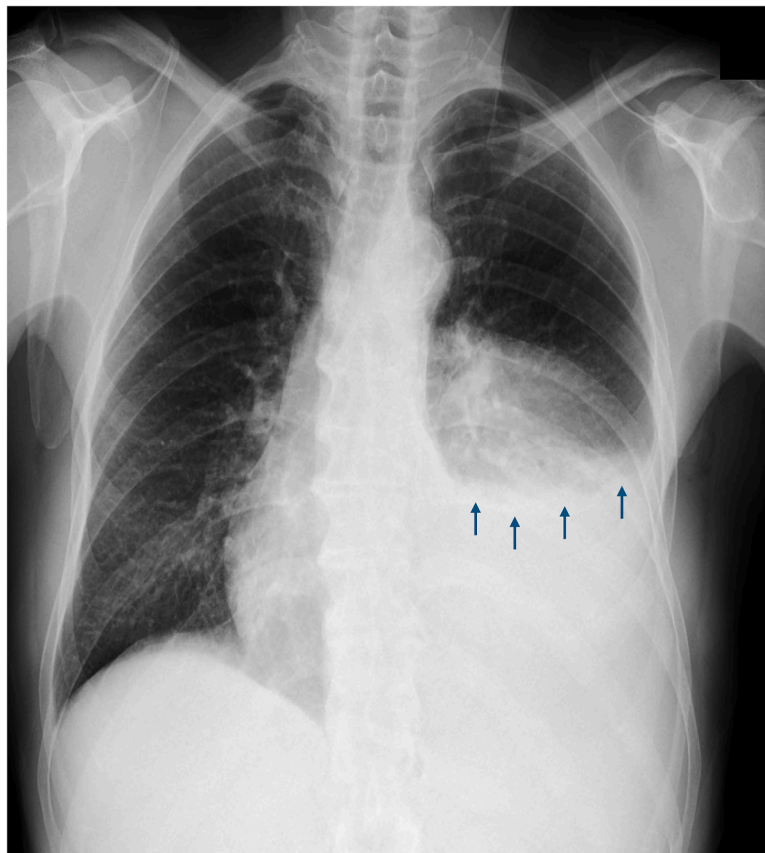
Posteroanterior chest X-ray, showing left lateral costophrenic and cardiophrenic effacement.
